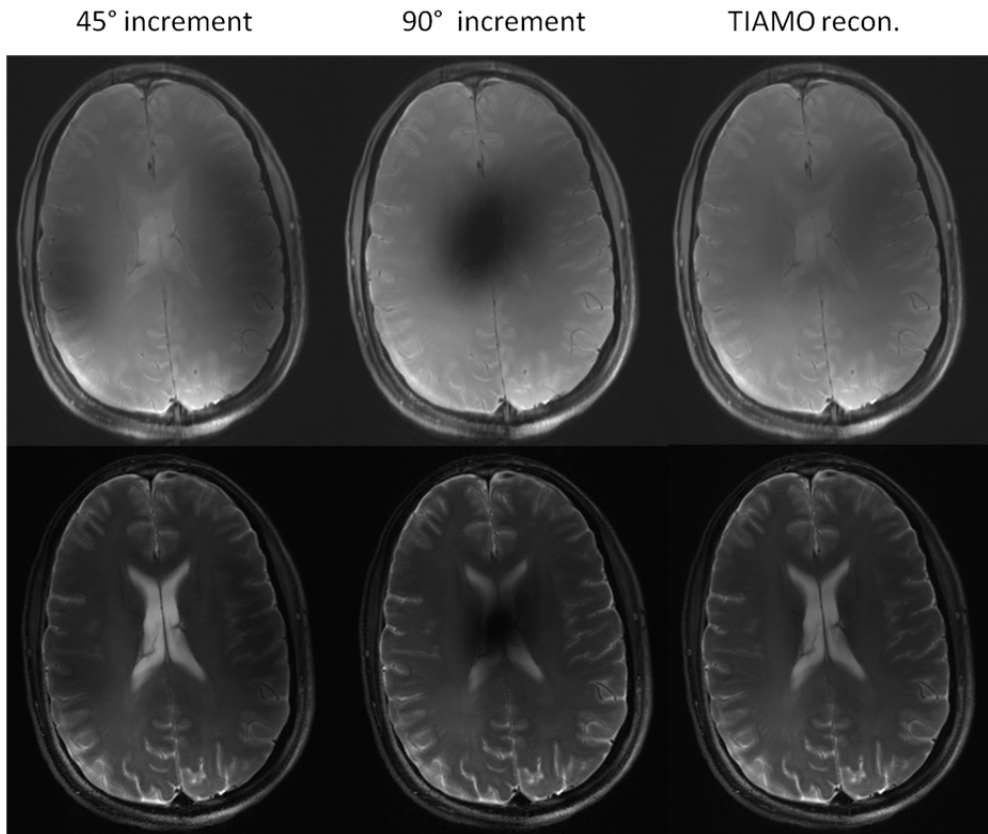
7T PD- (top row) and T2-weighted (bottom row) TSE in vivo brain images of a human volunteer. The TIAMO images with combined reconstruction contain less signal dropout and reveal superior tissue contrast. Note: the images are not intensity corrected.
